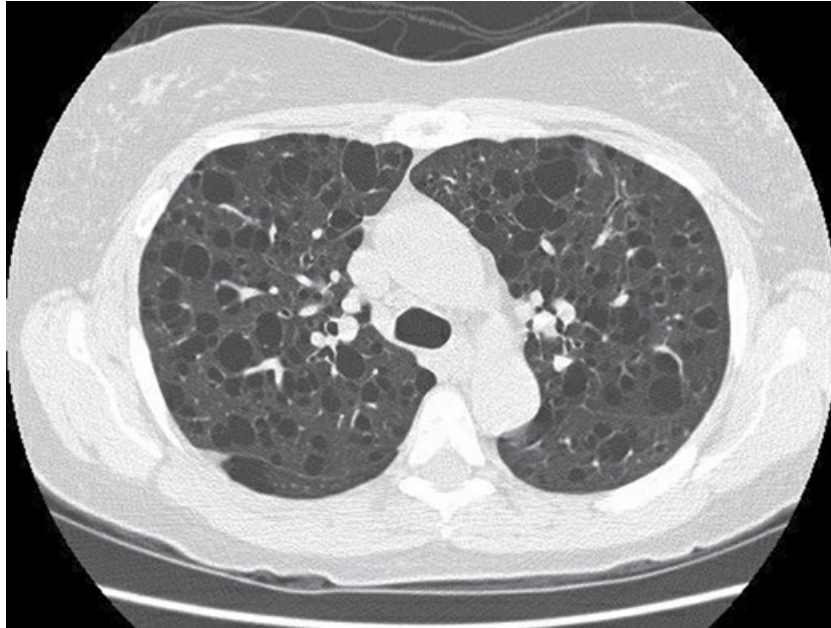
Chest CT scan showing countless cysts bilaterally in a patient with lymphangioleiomyomatosis. *Source:* (Courtesy Dr. Seth Kligerman.)
